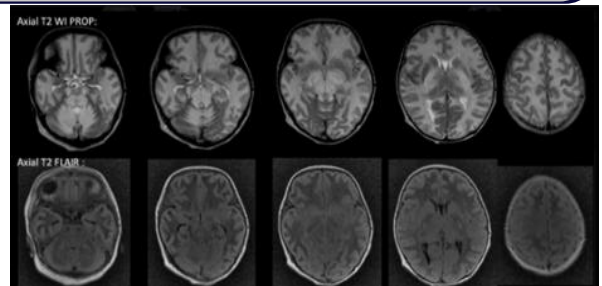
Axial T2-weighted and FLAIR images showing bilateral symmetrical hyperintensities involving the cerebellum, brainstem, thalami, and cerebral white matter suggestive of MSUD-related encephalopathy.
